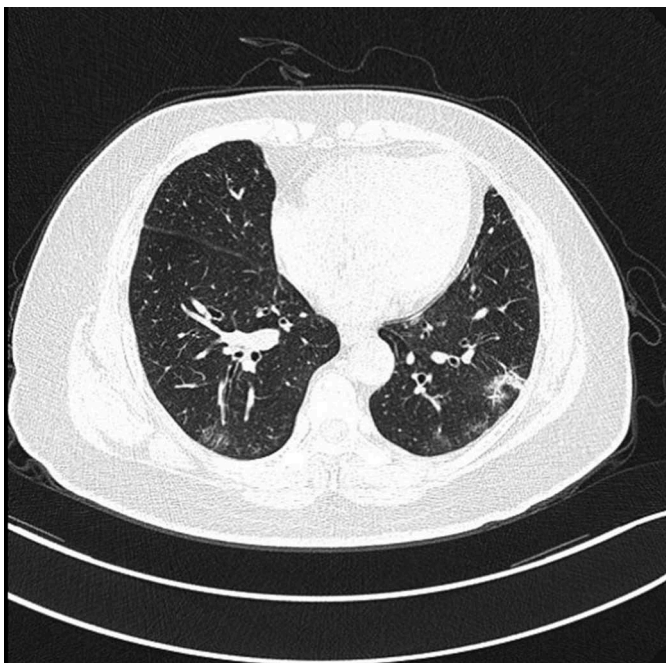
Chest CT of case 2, on 30 January 2020.
